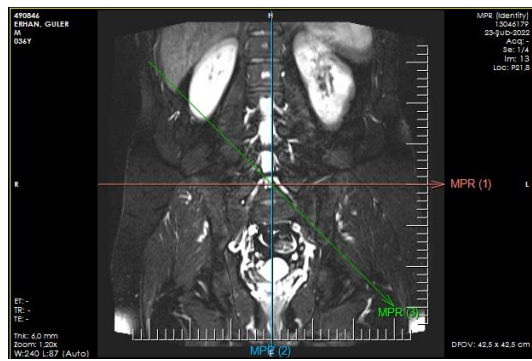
4. 1. MRI vertebrae distance
